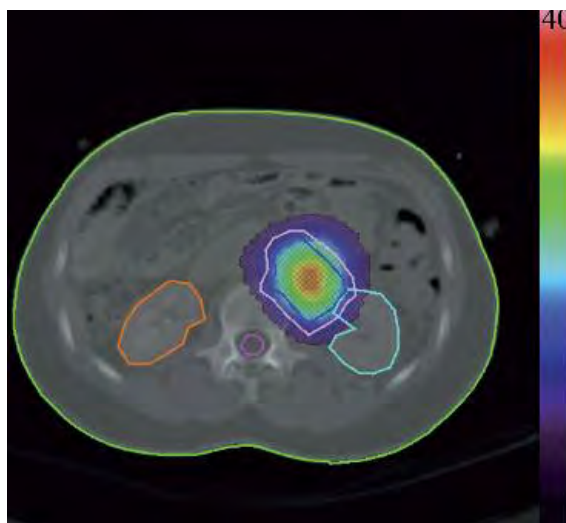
A parametric absorbed dose distribution superimposed onto a CT map, showing a maximum of 40 Gy. The 3D absorbed dose was determined from sequential SPECT scans. Outlines indicate the gross tumour volume, the planning target volume, the kidneys and the spinal cord as delineated on planning CT. The spread of absorbed dose outside of the target volume is due to the partial volume effect, so it is clear that the spinal cord is not being irradiated.
